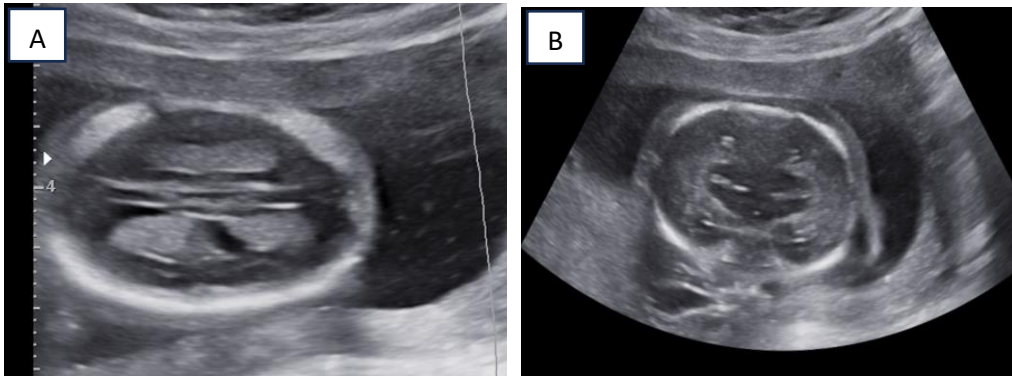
2D ultrasonography results in a) Arrows indicate two choroid plexuses, b) Two fetal heads fused at the thalamus.
